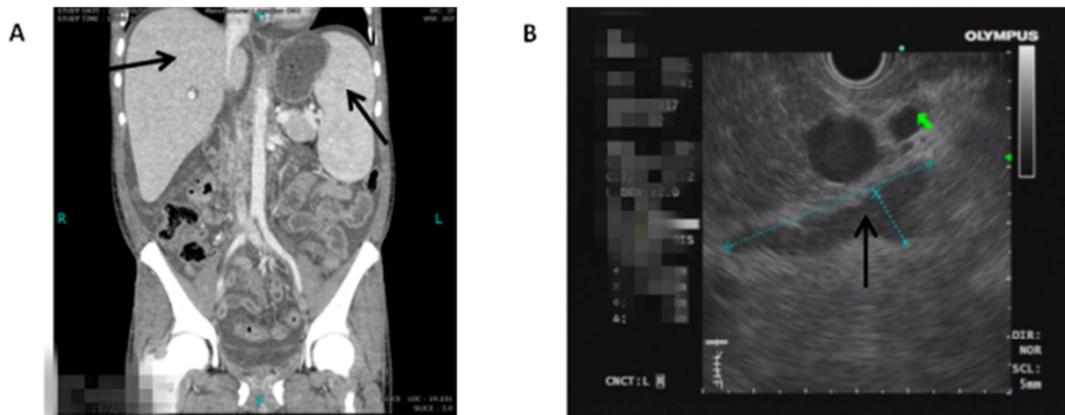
A. CT scan of the abdomen showing hepatosplenomegaly (black arrows). B. Ultrasound of gastroscopy showing the echo of the left adrenal gland is homogeneous (black arrow).
